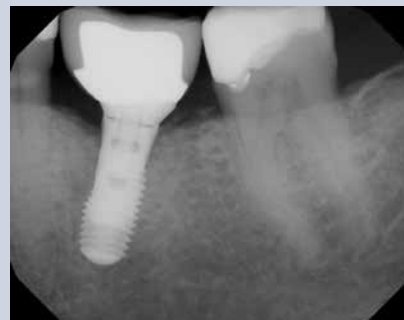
Six month post-operative radiograph demonstrating nearly complete regeneration of the defect.
